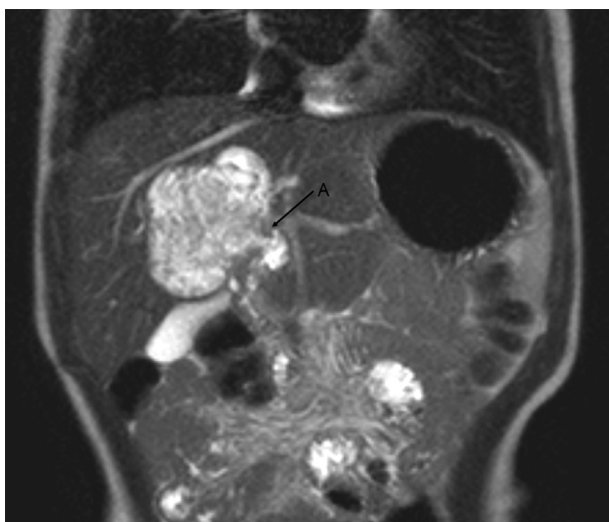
Abdominal MRI shows an intrahepatic cyst mass with a stalk (A).
